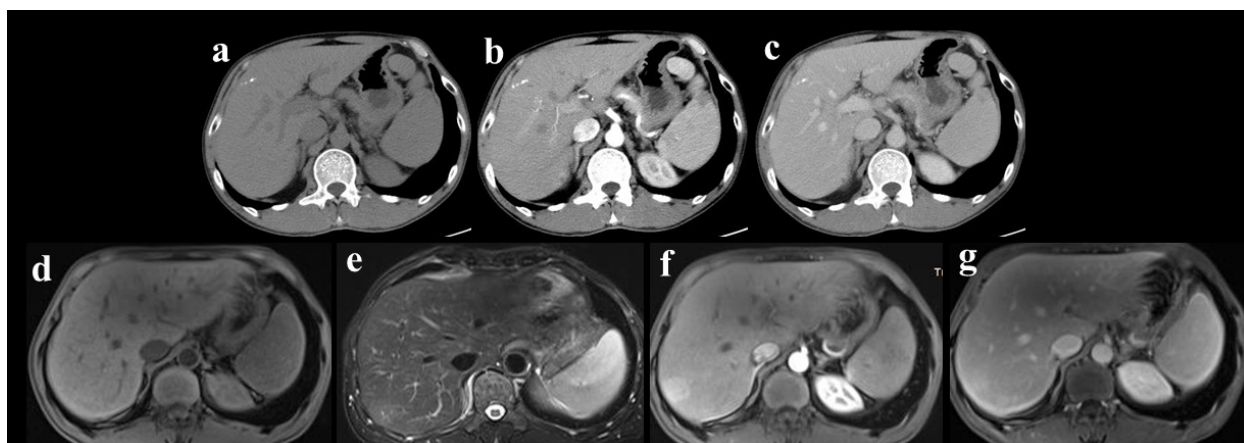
Imaging features of FNH in the case 1. (a-c) On multiphase CECT, no abnormal liver lesions were found, except for intrahepatic bile duct stones or calcification. (d-g) On conventional CE-MRI, a mass was not well-circumscribed in the 7th segment of the liver, which showed isointensity on T1-weighted images (d), slight hyperintensity on T2-weighted images (e), homogeneous and strong hyperintensity on arterial phase (f), and slight hyperintensity on portal phase (g).
